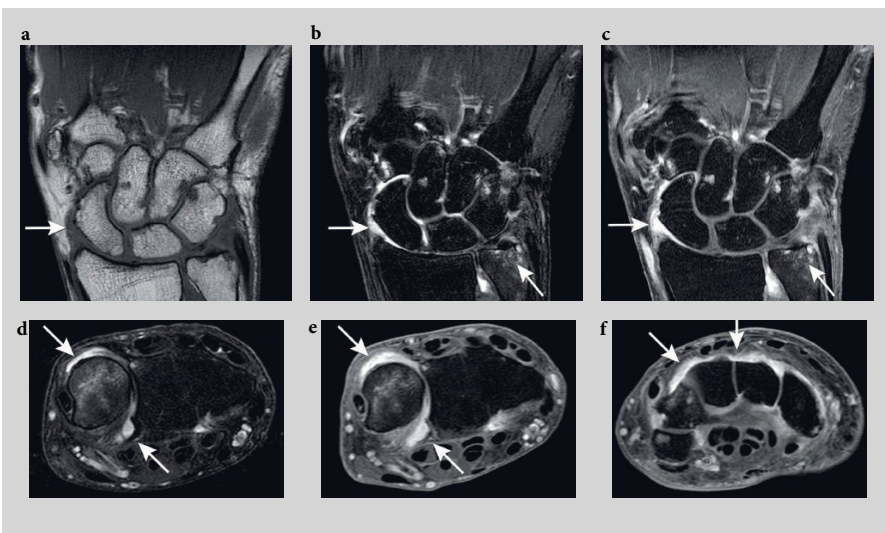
Magnetic resonance images (MRIs) of the right wrist in patient with undifferentiated arthritis and synovitis, intraosseous edema and erosions. Coronal T1 TSE (a), coronal and axial T2 TSE fat saturation (fat sat) (b,d) and coronal and axial T1 TSE fatsat with gadolinium (c, e, f). Multiple cortical erosions are visualized on T1 in the carpal bones and ulnar styloid process (a). On T2 (b) high signal intensity is present in the intercarpal, radiocarpal, and distal radial ulnar joints which enhances after contrast administration (c) (arrows), based on synovitis. Notice the intraosseous edema (bone marrow edema) and the enhancing erosions in the ulnar styloid (arrow). The high signal on T2 (d) is enhancing synovium (e) seen around the ulna and in the distal radial ulnar joint (arrows), as well as on the dorsal side of the carpalea (f).
